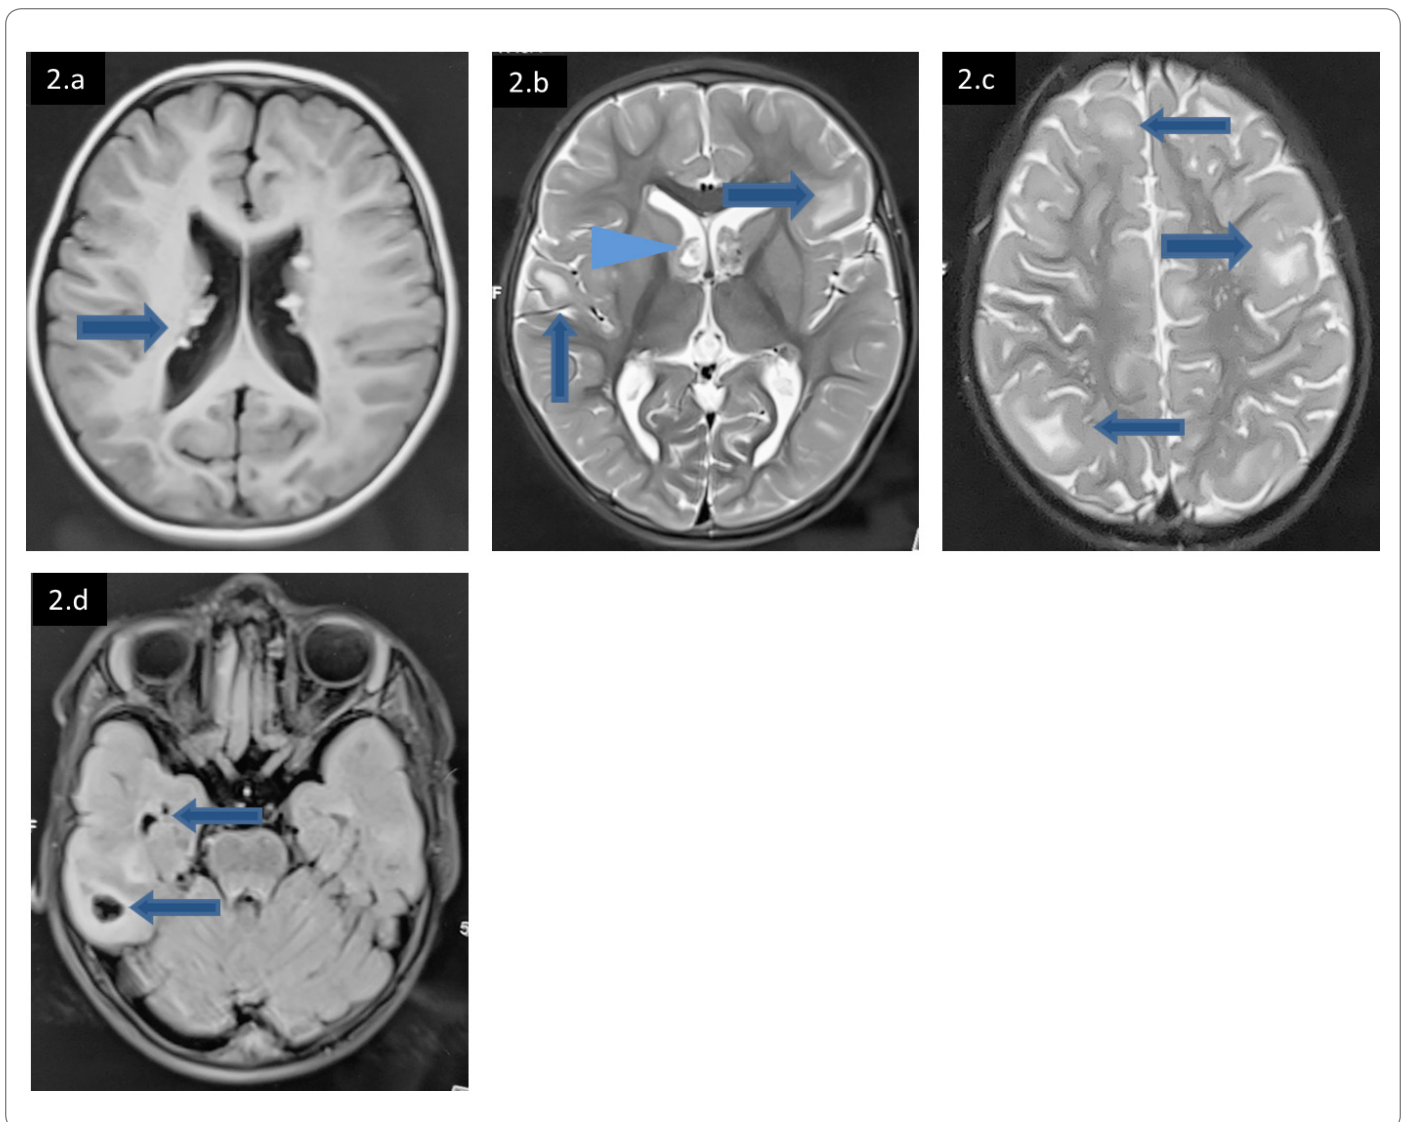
MRI brain of second child shows SENs (2a), SEGA at the level of foramen of Monro (2b, blue arrow head), multiple T2 hyperintense cortical tubers (2c, blue arrow), FLAIR sequence (2d) shows cystic cortical tubers in right temporal lobe.
